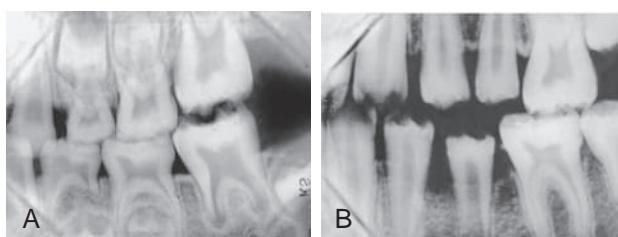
(A and B) Left bite wing radiographs of a patient with amelogenesis imperfecta. Radiograph in B was made 6 years after radiograph in A and demonstrates the maintenance of a caries-free dentition despite the thin enamel.
